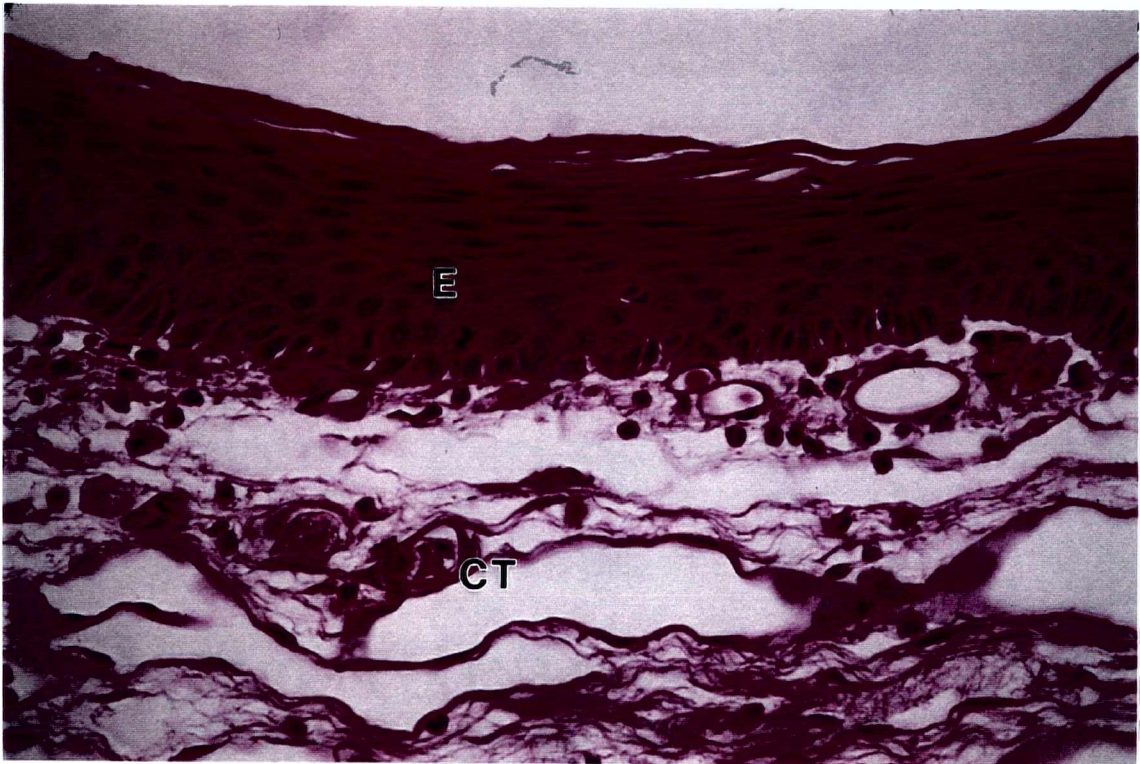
Keratinized oral epithelium; E=Epithelium, CT=Connective tissue
